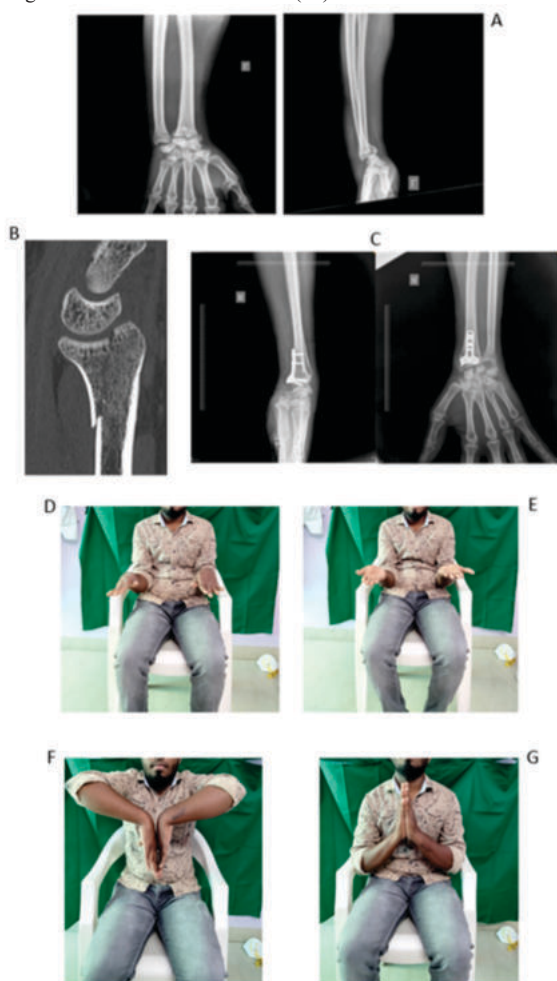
A, Preoperative X rays; B, Preoperative CT image; C, Postoperative X rays; D, Pronation; E, Supination; F, Palmar flexion; G, Dorsi flexion
